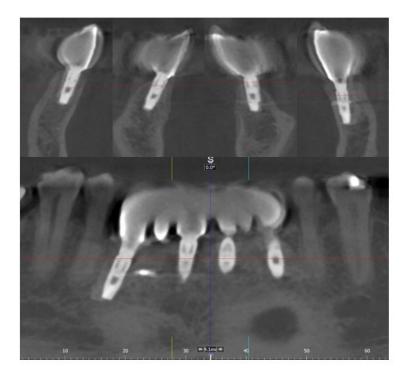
CBCT scan at 8-month follow-up. The radiological image shows successful osseointegration of the four implants and stable regenerated bone in the anterior mandible. No pathological findings are present.
